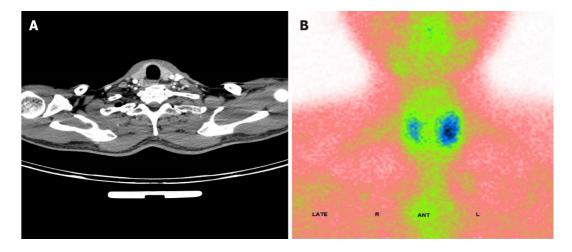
Imaging of lesions of the thyroid and parathyroid glands. A: Enhanced computerized tomography image showing a blood-rich nodule in the posterior left lobe of the thyroid gland; B: Emission computed tomography revealed a hyperfunctional lesion change in the left lobe of the thyroid gland.
